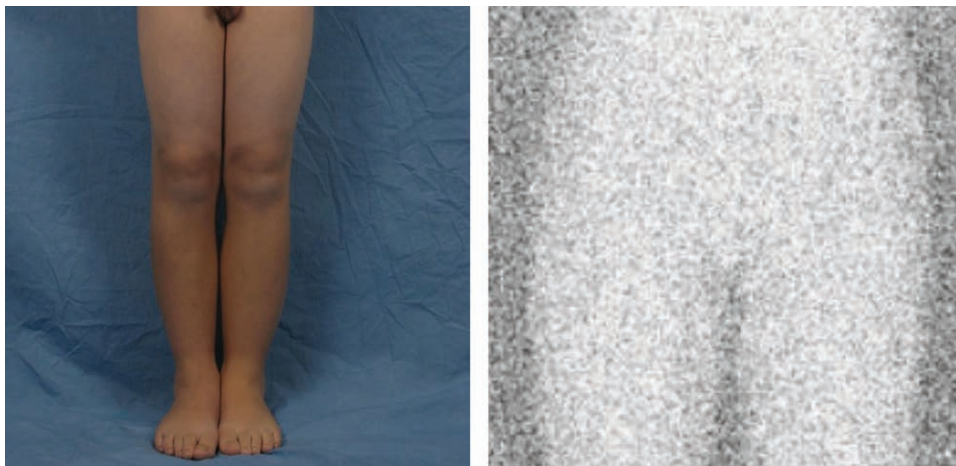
True-positive lymphoscintigram result. An 11-year-old boy with a history and physical examination consistent with primary lymphedema. Lymphoscintigraphy confirmed the diagnosis and showed absence of tracer in the inguinal nodes 4 hours after injection (normal transit time is less than 1 hour).
